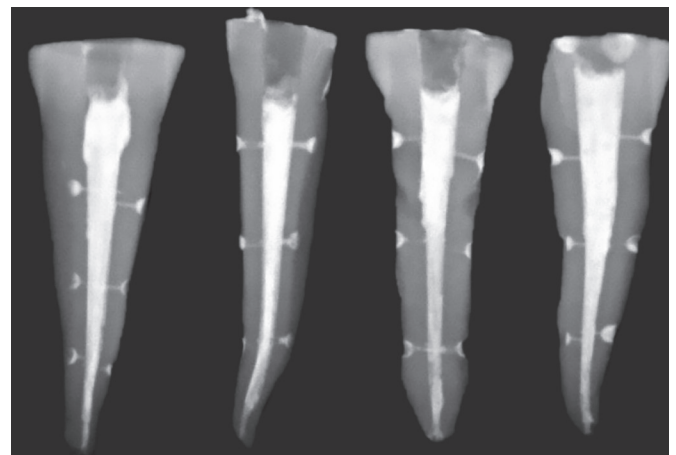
Digital radiograph of mandibular premolars obturated with AH Plus sealer
